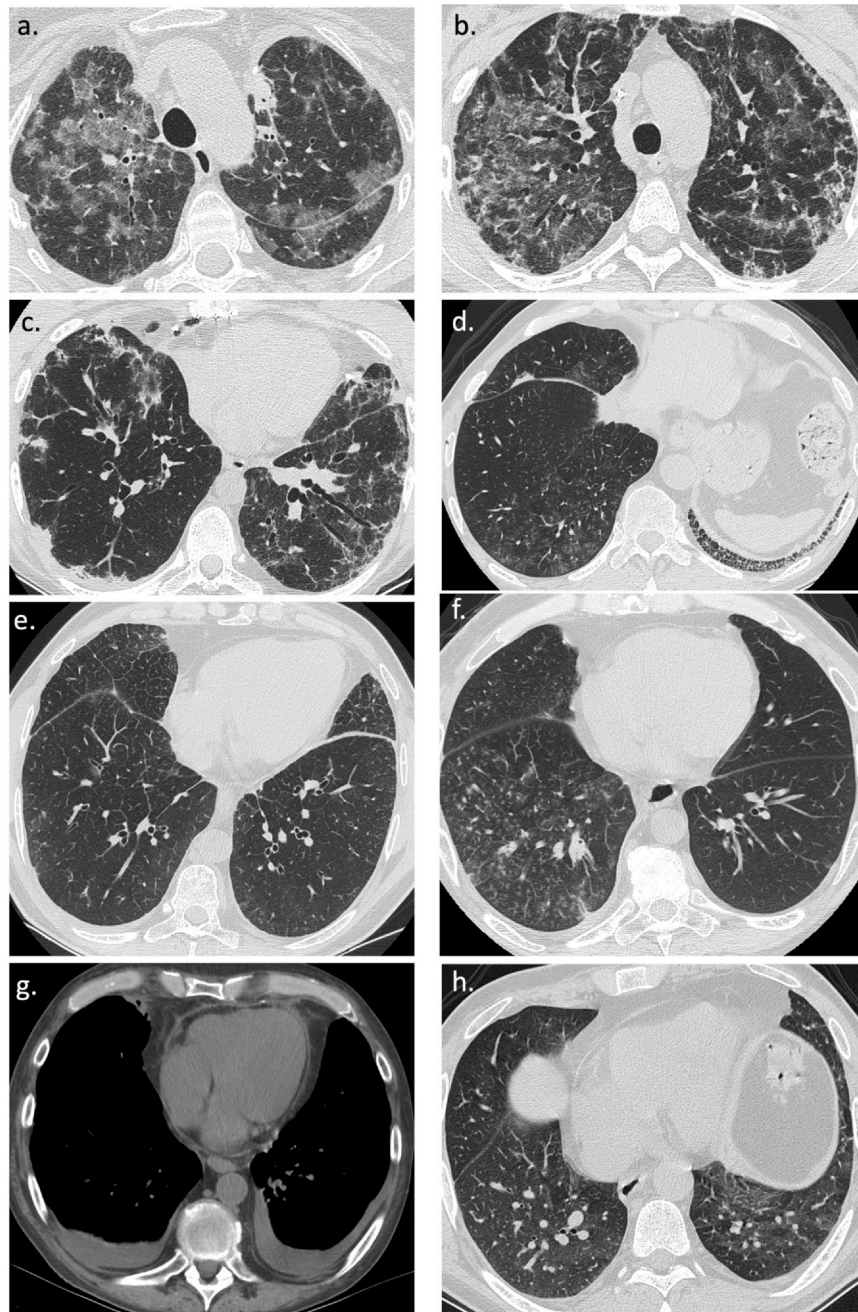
The main radiological characteristics of i-ALAD at CT scan. A: Intralobular ground-glass opacities in the upper lobes, accompanied by smooth intralobular septal thickening. B: intralobular ground-glass opacities in the upper lobes, accompanied by traction bronchiectasis and irregular septal thickening. C: basal subpleural consolidations associated with irregular septal thickening and traction bronchiectasis/bronchiolectasis. D: basal ground-glass micronodules on the right, associated with minimal smooth septal thickening. E: smooth interlobular septal thickening and bronchial wall thickening. F: Diffuse centrilobular ground-glass micronodules in the right lower lobe. G: Bilateral pleural effusion. H: Lobular air trapping in expiratory scans.
